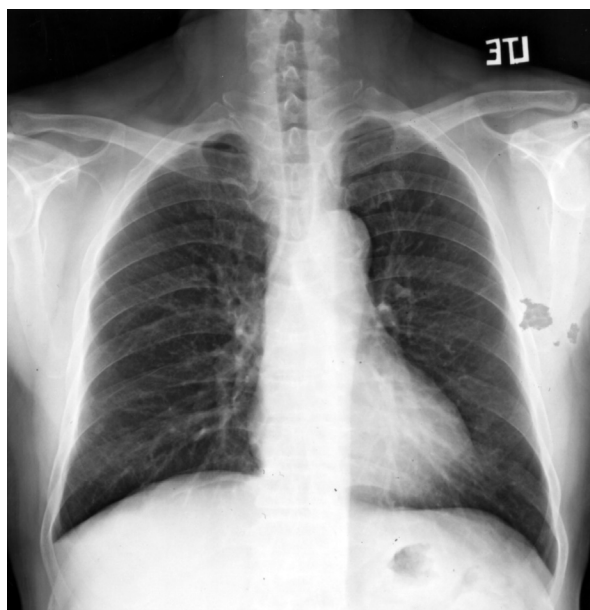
One week after discharge, chest x-ray revealed complete resolution of the right hilar mass and subsidence of the widened mediastinum.
